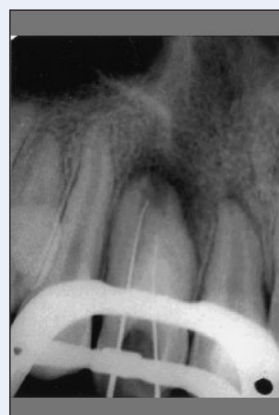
Radiograph with K-files in both canals.
